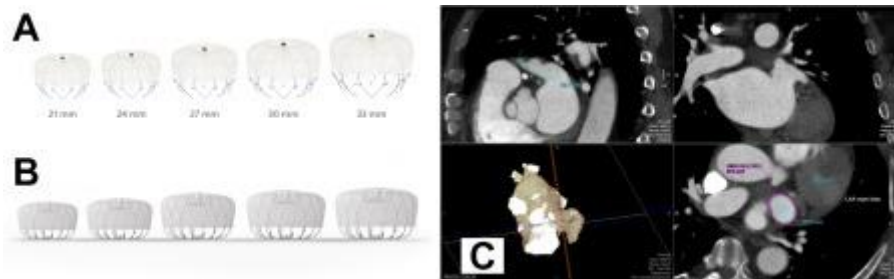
(A) The WATCHMAN device is produced in various sizes, as shown above. (B) The WATCHMAN FLX comes in the following sizes from left to right: 20 mm, 24 mm, 27 mm, 31 mm, and 35 mm. (C) CT-guided LAA sizing to aid in choosing the appropriate device size.
